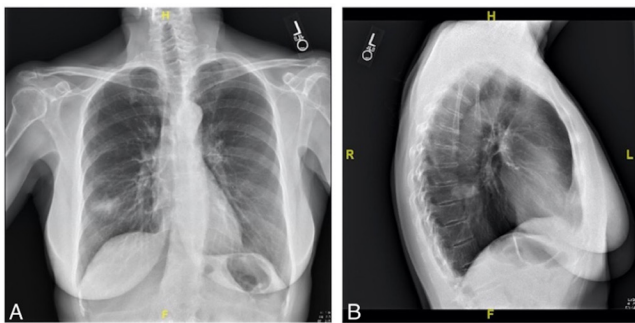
(A) and (B) Chest X-ray posteroanterior and lateral with 4.0×3.9×2.1 cm spiculated lung mass in the right lower lobe.
